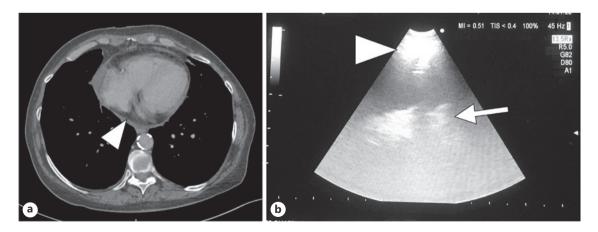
a CT scan with pericardial effusion. The arrowhead shows fluid in the posterior pericardium. b EUS-B picture of the needle in the pericardial effusion. The arrowhead shows the pericardium, and the arrow shows the myocardium.
